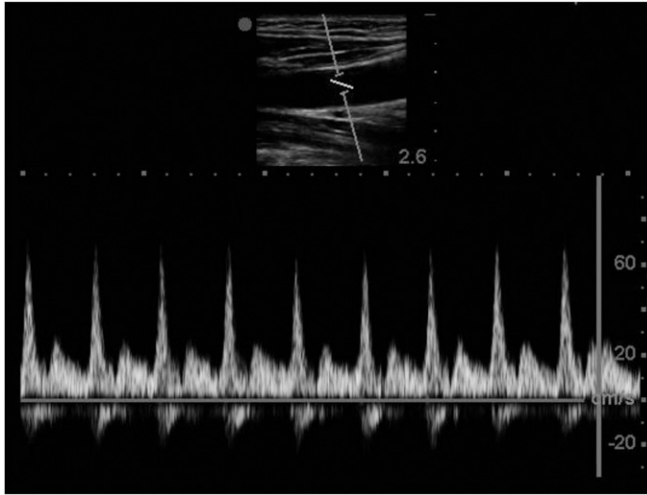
Spectral ultrasound. The vessel is imaged in B-mode with a gate positioned across the vessel (top). The spectral Doppler displays flow (cm/sec) versus time. This picture demonstrates the arterial waveform of the carotid artery.
